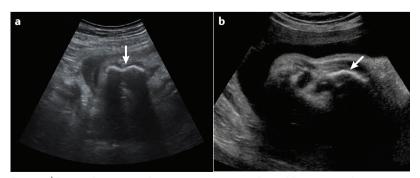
Prenatal screening for osteogenesis imperfecta. Ultrasonography images of two fetuses at 32 weeks (part a) and 33 weeks (part b) of gestation with genetically proven osteogenesis imperfecta demonstrating a severe bowing of the femur (arrows) in both cases and probably an intrauterine fracture in one of them (part a).
